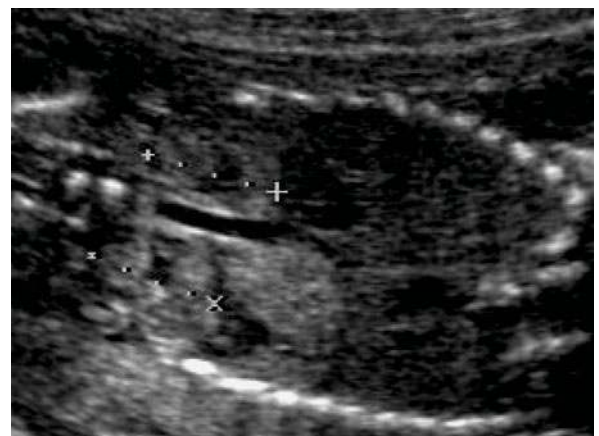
Right-sided microcystic CPAM. a At 20 weeks: right pulmonary hyperechoic lesion displacing the heart to the left. b At 32 weeks: decrease in lesion size and mediastinal shift. c CT at birth: RLL fluid-filled lesion
